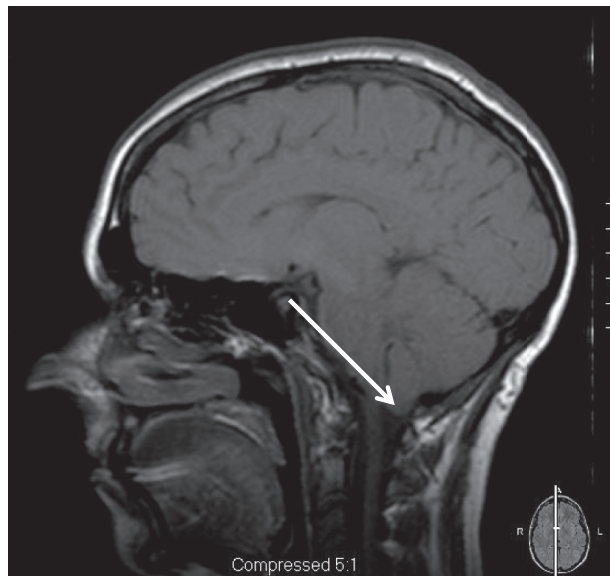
Tonsillar ectopia. T1-weighted sagittal image demonstrating the cerebellar tonsils (arrow) below the foramen magnum.
